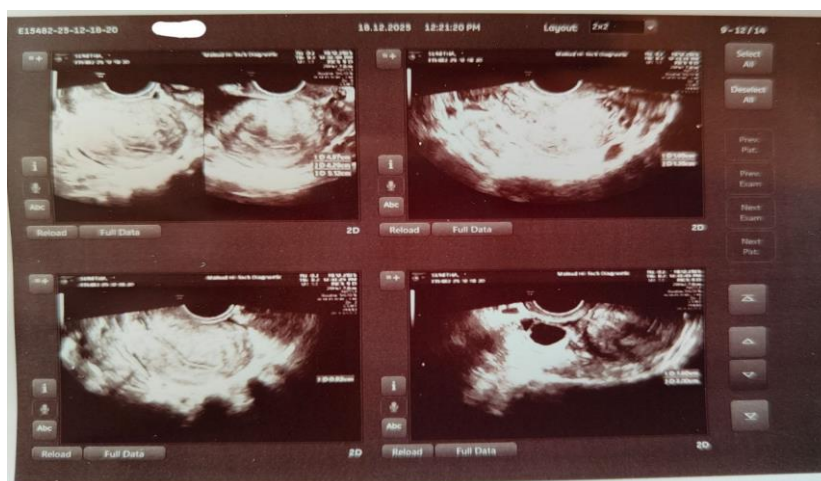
Post-intervention ultrasonographic images obtained on 18/12/2025.
